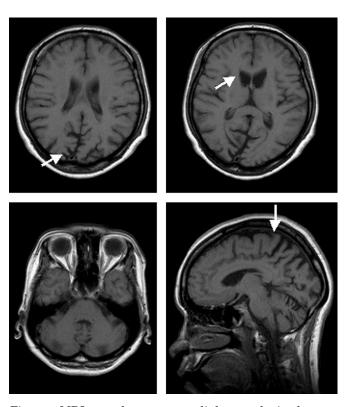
MRI scan demonstrates slight atrophy in the head of the caudate nucleus. Cerebral cortex of the occipital and parietal lobes also is atrophic.
